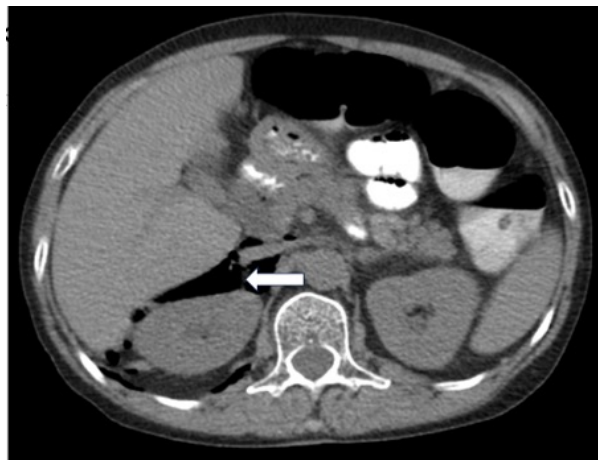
Computed tomography scan of patient 2 showing pneumoretroperitoneum around right perirenal space (white arrow)*
